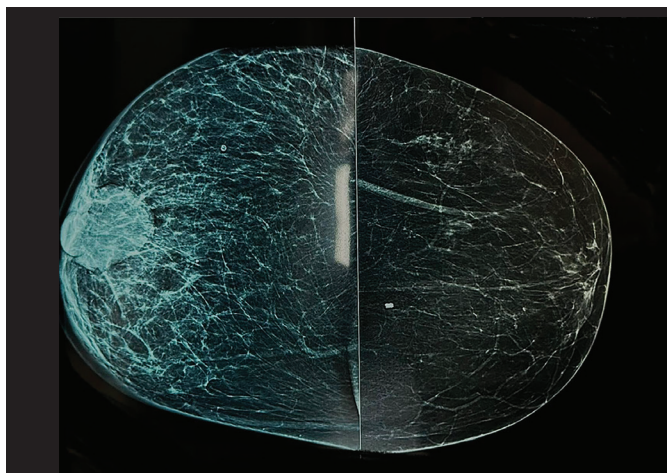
Digital mammography of the right breast revealing a retroareolar, radiodense mass with partially obscured borders and associated skin and interstitial thickening. The lesion measures approximately 5.5 cm in greatest dimension and was classified as Breast Imaging Reporting and Data System 5, indicating high suspicion for malignancy. A posterior density with similar morphology is also visible in the right breast, corresponding to a second malignant focus on magnetic resonance imaging (multifocal disease). Dense artifacts are visible only in the caudal subcutaneous area of the left breast mediolateral oblique projection, related to acquisition technique, without affecting diagnostic interpretation
